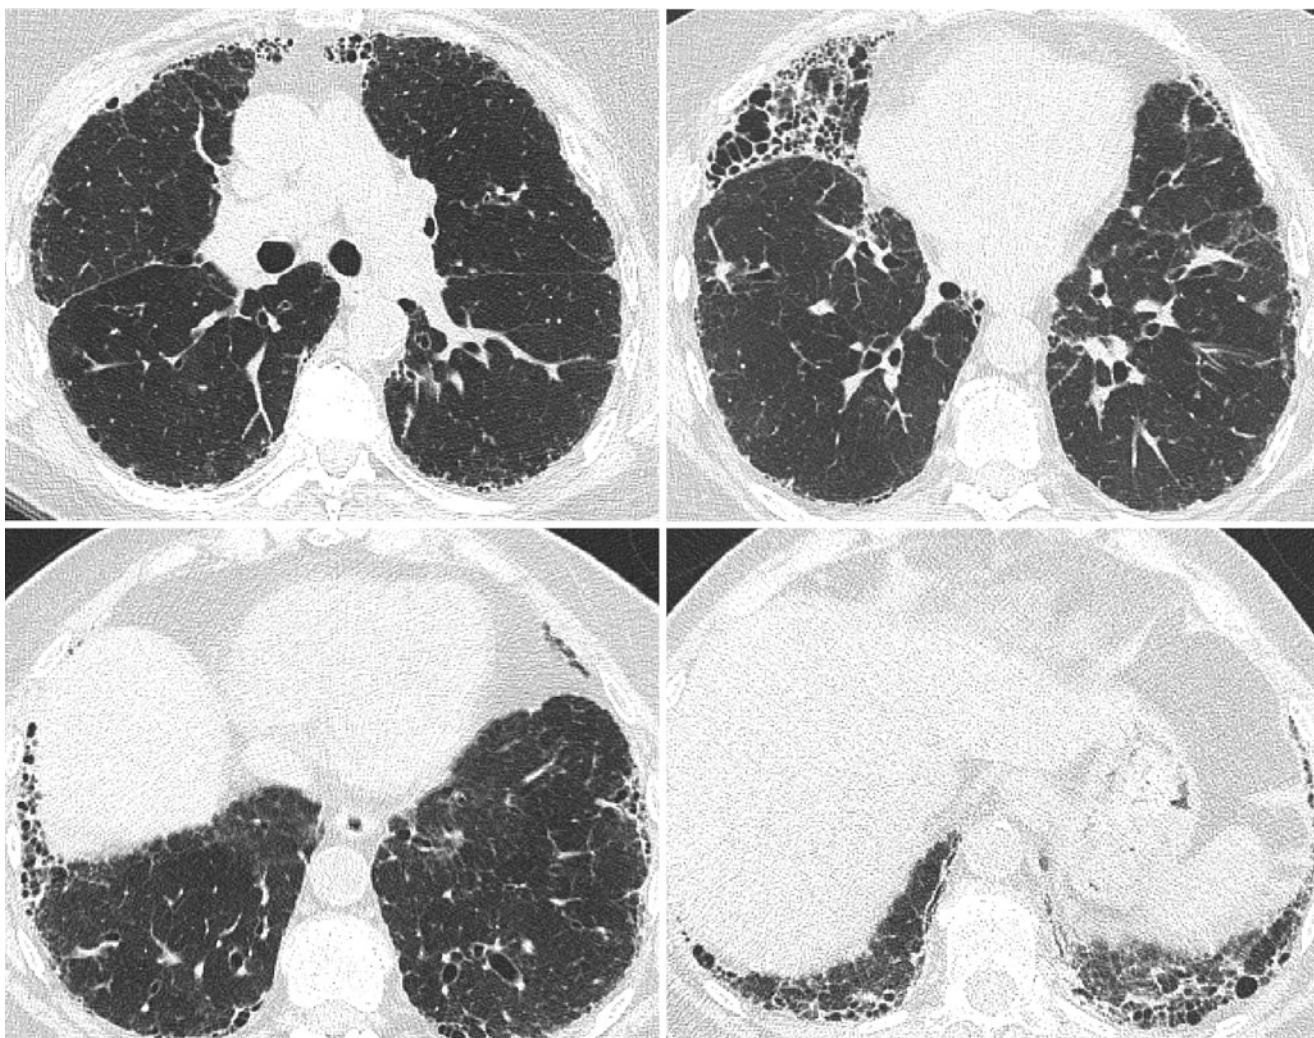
Transaxial chest CT in a patient with idiopathic pulmonary fibrosis showing a pattern of usual interstitial pneumonia, characterized by lower lung predominance of peripheral reticulation, traction bronchiectasis, and honeycombing
